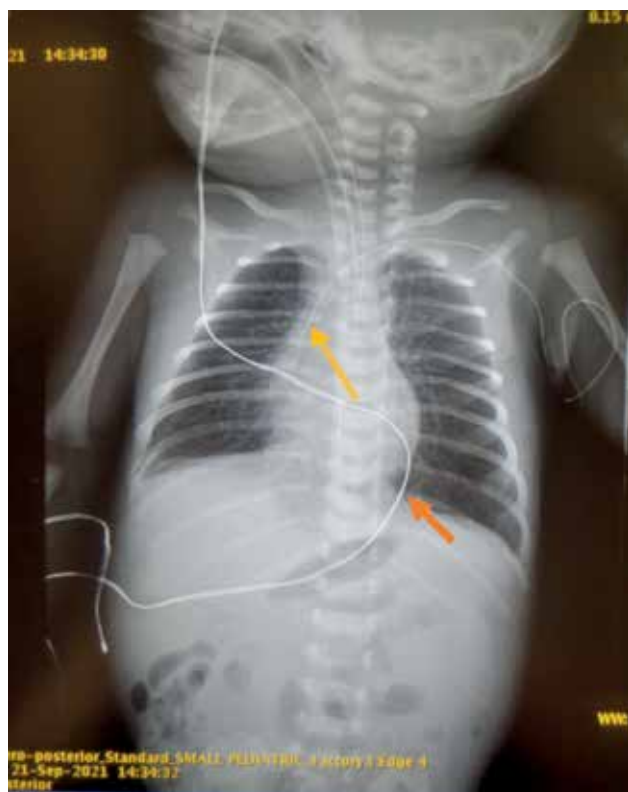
X-ray after replacement of PIC-line (yellow arrow), temperature sensor (orange arrow)
